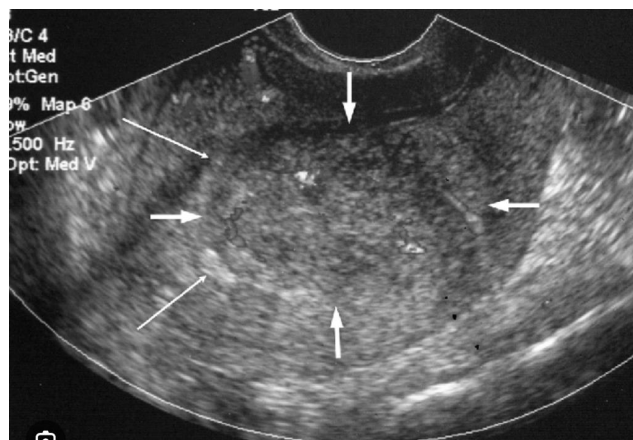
Ultrasound findings of low grade endometrial stromal sarcoma
